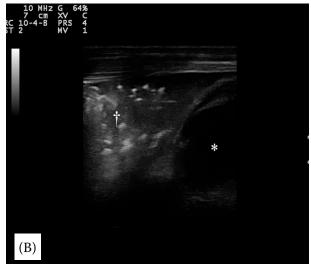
Ultrasonographic images of the cranial aspect of the left cranial lung lobe from the 3^{rd} intercostal space on the left (A) and of the caudal aspect of the right cranial lobe from the 4^{th} intercostal space (B) on the right performed with a 10 MHz linear transducer. Both lobes were affected by a full thickness consolidation (†). The heart is the ventral image landmark in both locations (*)
